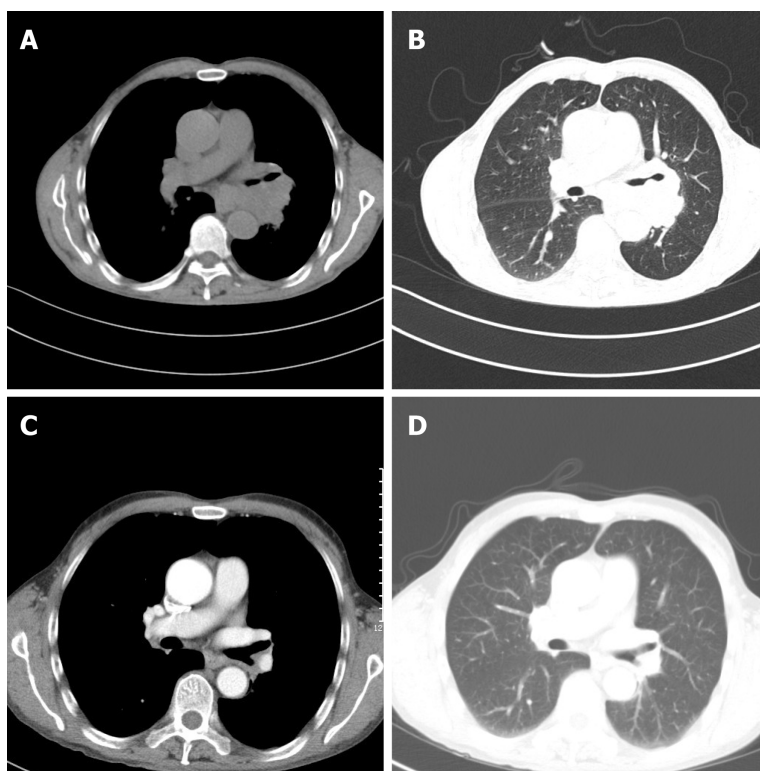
Computed tomography scan of the lung. A, B: Chest computed tomography (CT) images obtained before chemotherapy indicated a central lung cancer was present. A lobulated, low density hilar mass (indicated with arrows) was found to be pressing and narrowing the left main bronchus. No lymph node enlargement was seen in the mediastinum; C, D: Chest CT images obtained after three rounds of chemotherapy. The left hilar mass (indicated with arrows) exhibited a marked reduction in size.
